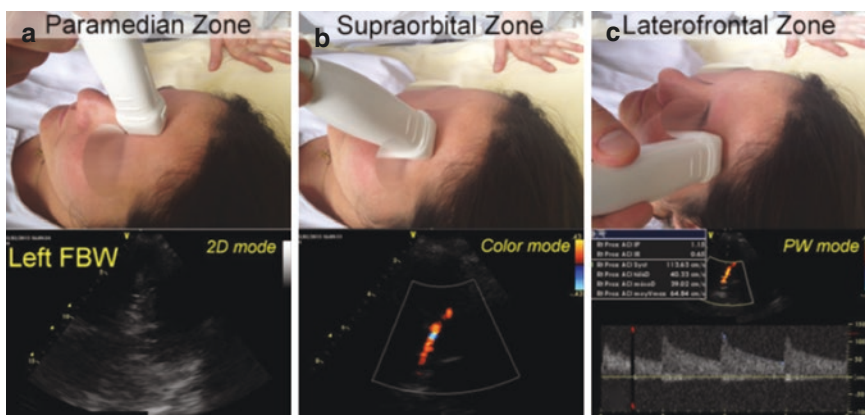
Frontal lobe window approach by TCCS: (a) (B-Mode: brain parenchyma) The transducer is positioned vertically at the paramedian frontal zone with probe mark at the top; (b) (Color Doppler: A2 segment of the ACA) Rotated the probe 90° outward and shifted horizontally with probe mark laterally to the supraorbital zone at the top of the orbital arcade; (c) Pulsed wave Doppler: blood flow velocity using pulsed Doppler. From the supraorbital zone slides laterally to access to the laterofrontal zone. (Modified from Sentenac et al. [69])
